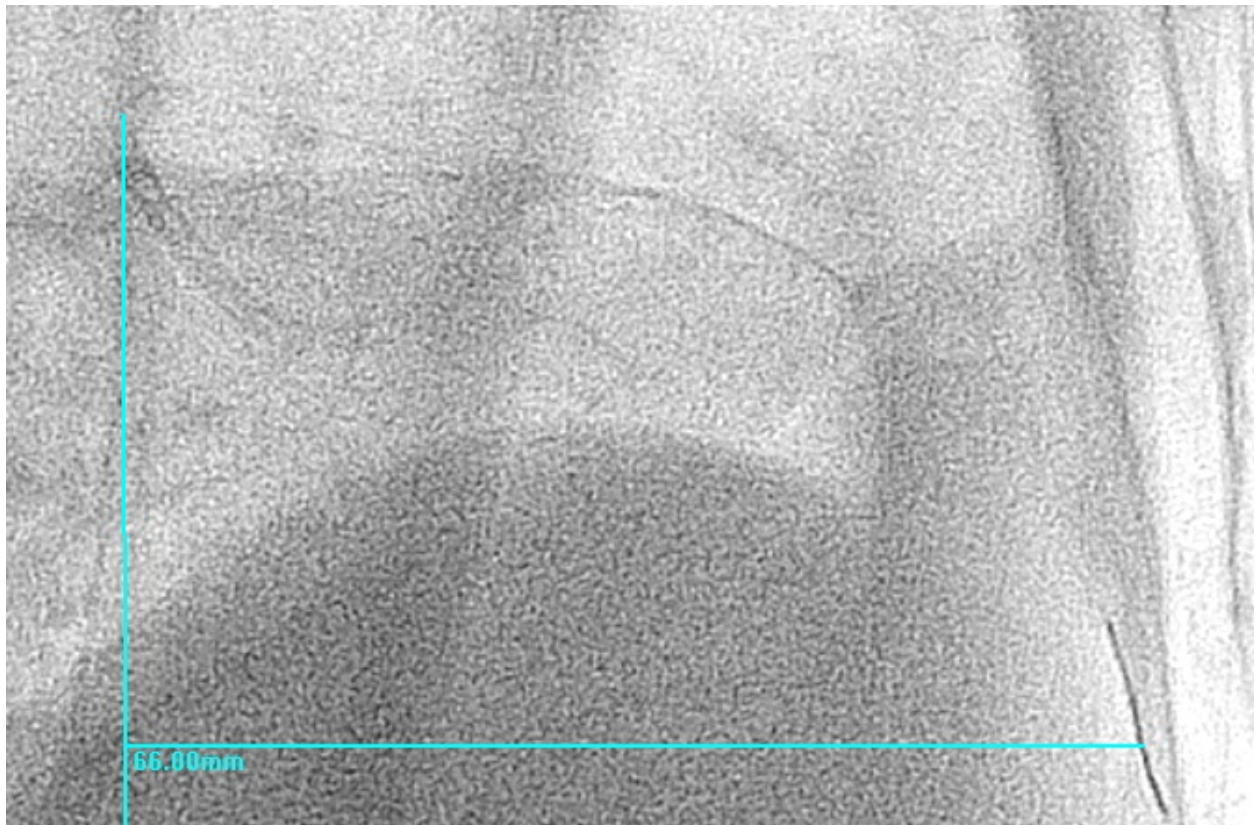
Guide to Wire Measurement - in the left lateral x-ray view between the guide catheter, top left, and the sensor on the wire, bottom right.
